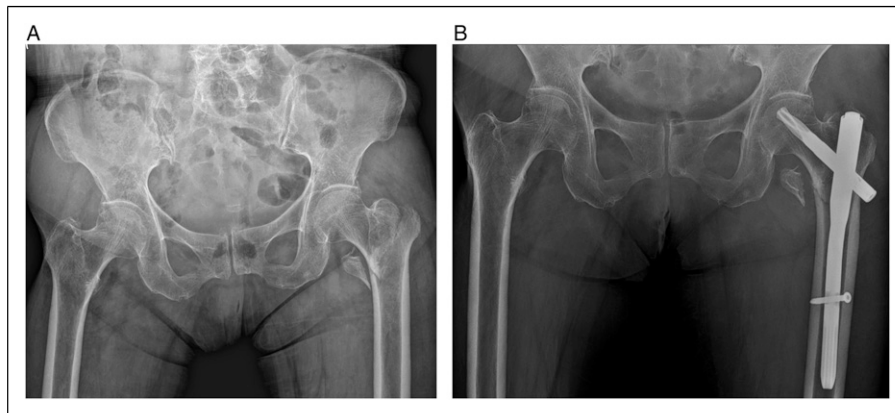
(A) Preoperative X-ray of the left hip intertrochanteric fracture. Anteroposterior radiograph showed AO/OTA classification A2.2 type intertrochanteric fracture. (B) Postoperative X-ray showed stable apposition of the medial cortex and correct position of blade with adequate tip-apex distance.
